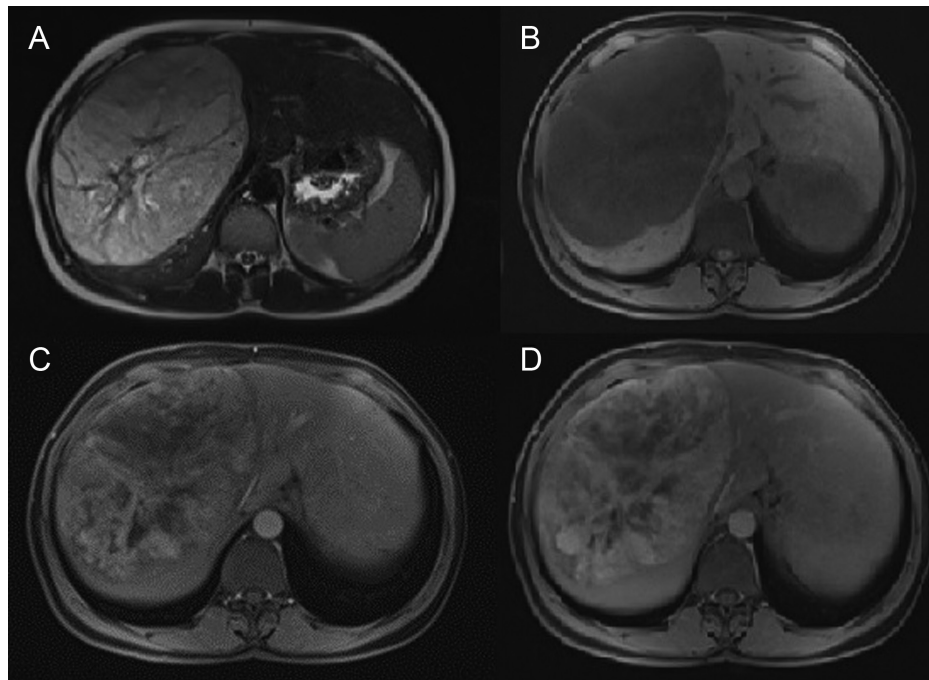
A-D. The lesion showed a slightly increased signal intensity on T2-weighted images (A: T2-weighted image) and slightly decreased signal intensity on T1-weighted images (B: precontrast T1-weighted image). A progressive uneven enhancement was observed after the infusion of contrast material (C: arterial phase; D: delayed phase).
